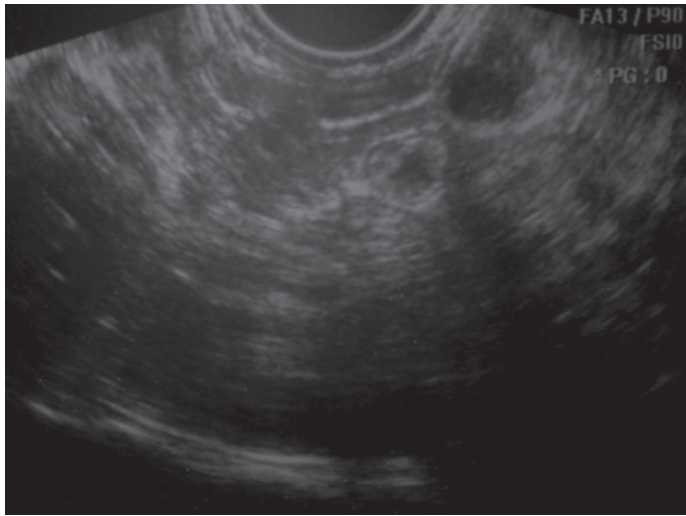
Transrectal ultrasound of the index patient revealing the absence of uterus and ovaries
